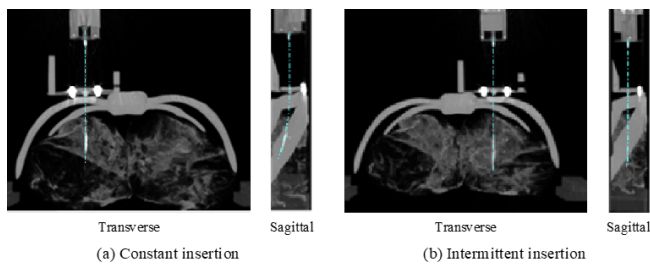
The representative CT images under applying (a) the constant insertion and (b) the intermittent insertion. Blue dot lines show the actual needle path.
